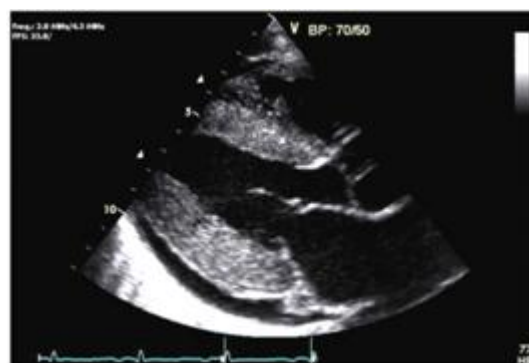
Echocardiogram of a patient with amyloidosis
